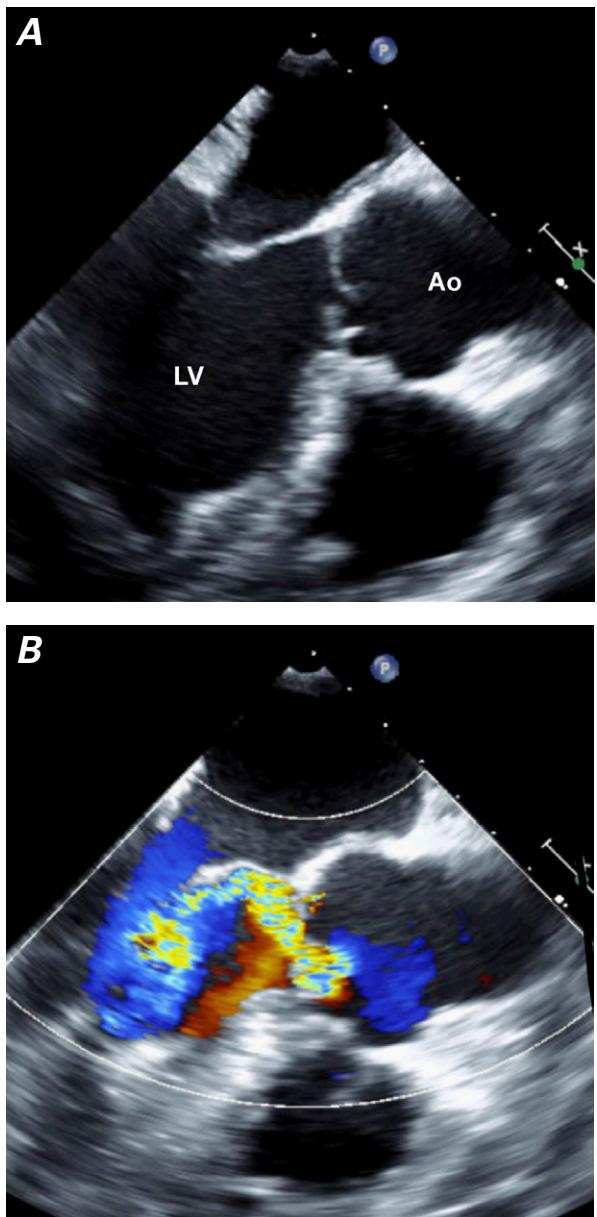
Transesophageal echocardiograms. A) Midesophageal long-axis view (135° rotation) shows a flail right coronary cusp. B) Color-flow Doppler mode reveals the resultant moderate aortic regurgitation.
